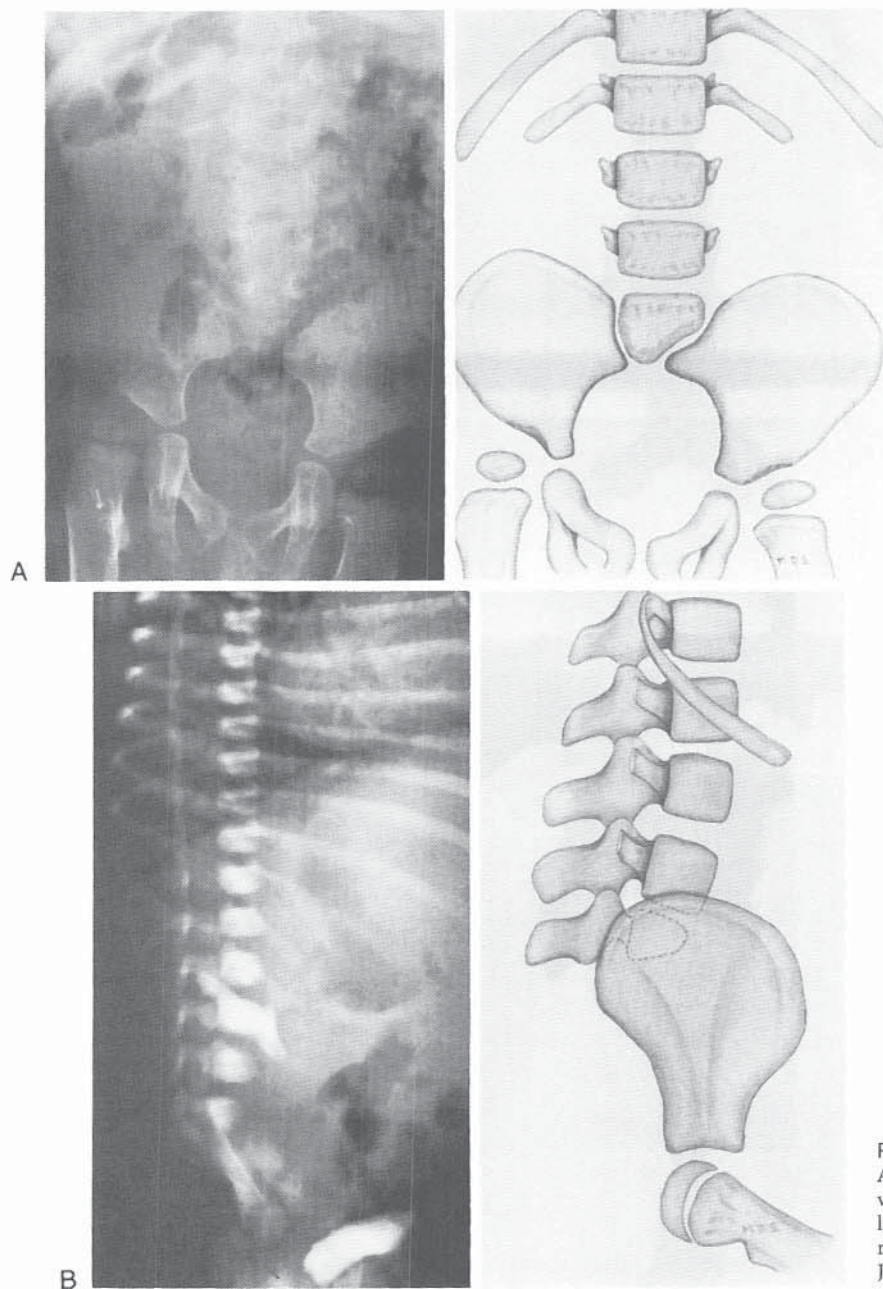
Type III lumbosacral agenesis. A, On the AP radiograph, the sacrum and lower lumbar vertebrae are absent. The third lumbar vertebra articulates with the pelvis. B, Appearance on the lateral radiograph. (From Renshaw TS: Sacral agenesis. *J Bone Joint Surg* 1978;60-A:373.)
